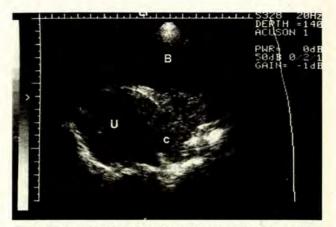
False-positive bladder ultrasound scan. In this case, both ultrasound examination and cystoscopy suggested bladder infiltration; biopsy showed cystitis cystica.
